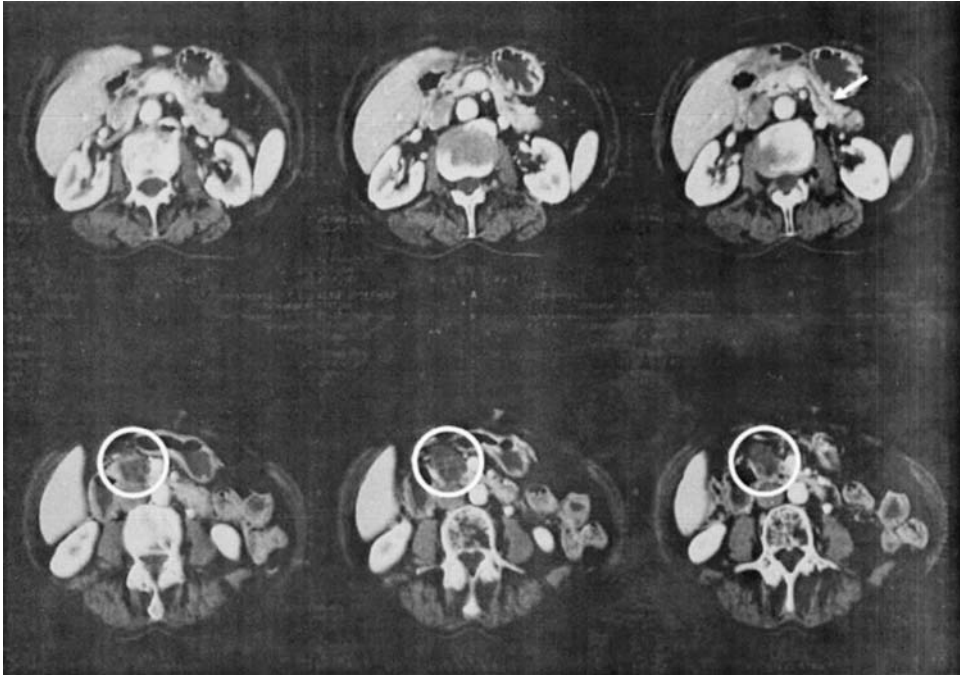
Abdominal CT of an 80-year-old woman who presented with abdominal pain. The patient underwent a pylorus-preserving pancreaticoduodenectomy; final pathology revealed a 3.5-cm IPMN with a small focus of carcinoma in situ located in the head of the pancreas. Notable findings on this series of images that are characteristic of IPMN include the multiloculated cystic mass in the right side of the pancreas (*circle*) associated with mild to moderate pancreatic ductal dilatation (*arrow*).
